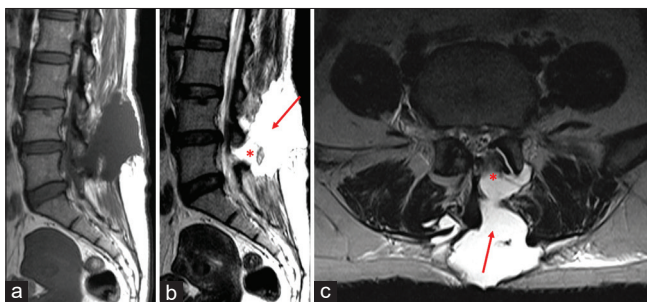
Postoperative pseudomeningocele – magnetic resonance imaging of the patient showing post-L4–L5 discectomy pseudomeningocele measuring 5 cm × 4.2 cm × 4 cm, ill-defined cerebrospinal fluid collection extending into the paraspinal region on the left side. *Dural defect, Arrow: Cerebrospinal fluid collection. Sagittal T1-weighted (a), Sagittal T2-weighted (b), Axial T2-weighted (c)
